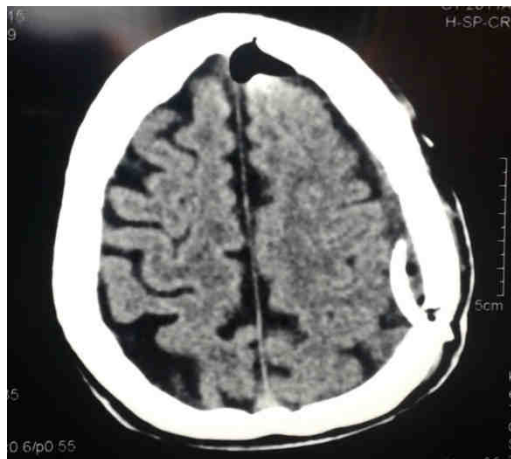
A.M. – CT native aspect 24 hours post operatory
